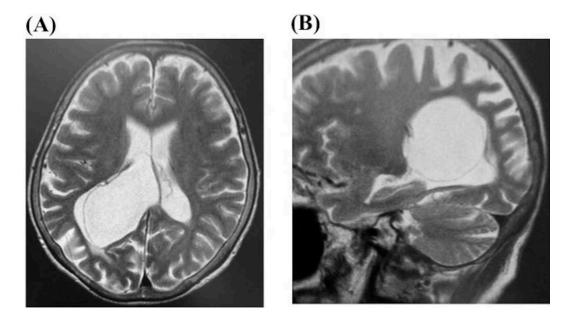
A 54-year-old female associated with headache and mild burred vision on her left showed a large arachnoid cyst in the right lateral ventricle on MRI (A; coronal section and B; sagittal section on T2WI). Her symptom improved after endoscopic fenestration between the lateral ventricle and the cyst.
